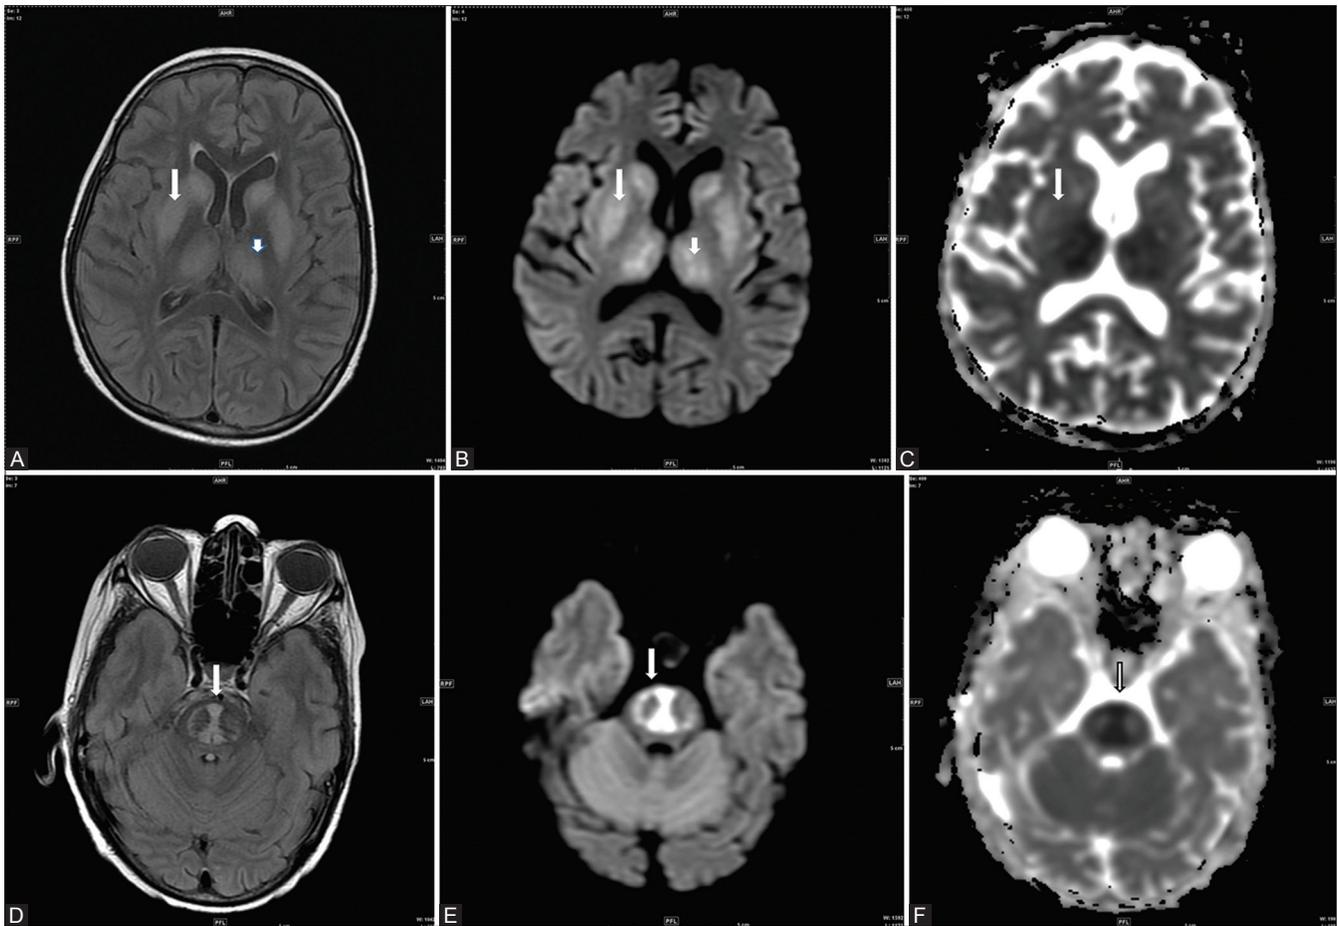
Case 2 (2nd MRI - 9 days after correction of hyponatremia) (A) Axial FLAIR section at the level of basal ganglia shows hyperintense signal in both caudate heads and putamina as well as in thalami (B) Axial DWI section at the level of basal ganglia shows hyperintense signal in both caudate heads and putamina as well as in thalami (C) Axial ADC map at the level of basal ganglia shows high ADC values suggestive of decreased diffusion restriction and T2 shine through effect (D) Axial FLAIR section at the level of pons shows trident-shaped hyperintensity within central pons (E) Axial DWI section at the level of pons shows strong diffusion restriction in pons (trident-shaped) (F) Axial ADC map at the level of pons shows low ADC values suggestive of strong diffusion restriction (central pontine myelinolysis)
